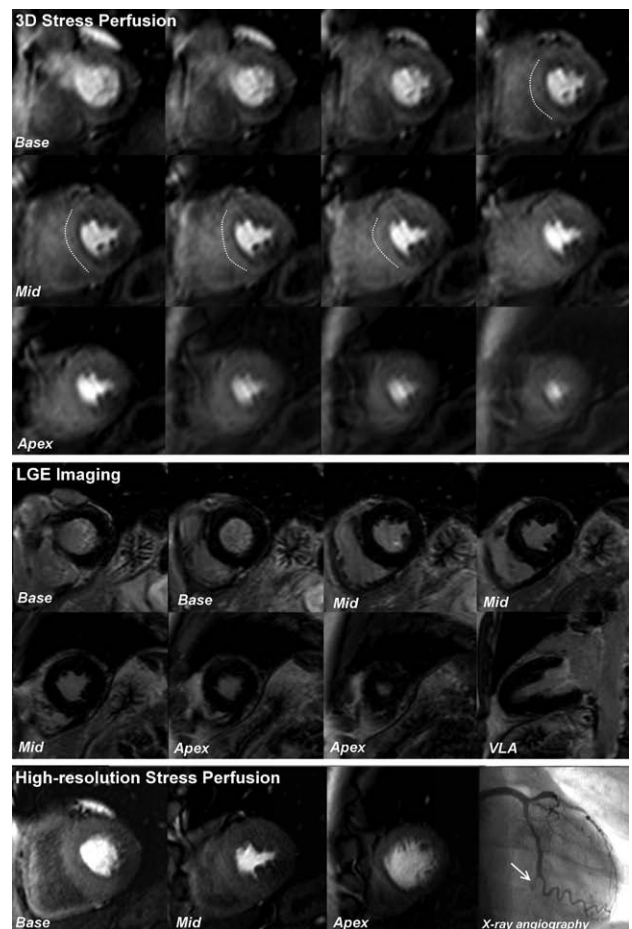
Case example 4. The top panel dimensional shows stress 3-dimensional (3D) perfusion cardiovascular magnetic resonance (CMR; 12 slices); the middle panel shows late-gadolinium enhancement imaging; and the bottom panel shows high-resolution (1.1 mm in-plane) stress perfusion CMR, all performed at 3.0 T. The 3D technique demonstrated significant stress-induced hypoperfusion in the inferior wall from base to apex and extending into the basal inferolateral segments; but there was also significant dark-rim artifact in the septum (endocardial border opposite dashed lines). X-ray angiography confirmed total occlusion of the mid left circumflex artery (arrow). Because of the sparsity of coverage, the 3-slice high-resolution technique only detected a significant perfusion defect at the mid-ventricular level, and therefore significantly underestimated the ischemic burden in this case compared with the 3D technique. Additionally, interpretation of the apical high-resolution slice is difficult because it is significantly more diastolic than the other slices, which is a disadvantage of all 2D acquisitions that use a single-shot technique. By comparison, with 3D perfusion CMR, all slices are acquired at the same point in the cardiac cycle, which makes it easier to determine the extent of perfusion defects across different myocardial sections. VLA indicates vertical long axis.
